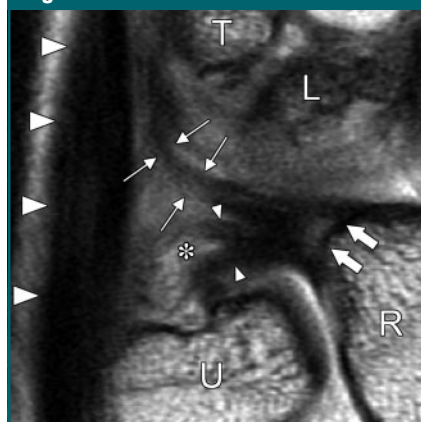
Coronal intermediate-weighted MR image shows radioulnar component (thin arrows) of the UMH at the level of the origin of the dorsal radioulnar ligament. The broad ligamentous structure attaches to the dorsal edge of the radial notch (thick arrows) and divides into the proximal and distal lamina of the TFC (small arrowheads), separated by the ligamentum subcurvatum (*), and the radioulnar component. Large arrowheads point to ECU tendon. L = lunate bone, R = radius, T = triquetrum, U = ulna.
